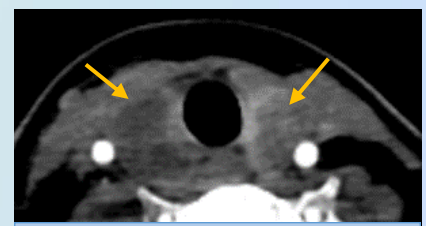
Axial post-contrast CT neck showed hypoenhancing thyroid lesions (arrows).
